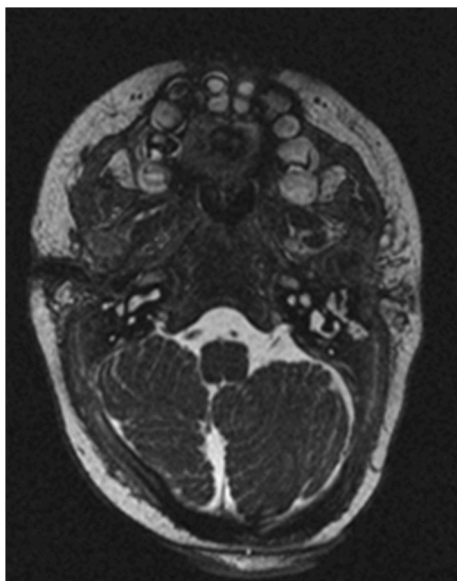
MRI of ear and temporal bone (patient 7) showing signs of atresia of the external auditory canals, dysplasia of the right lateral semicircular canal and non-characterization of the facial and vestibulocochlear nerves on the right.
